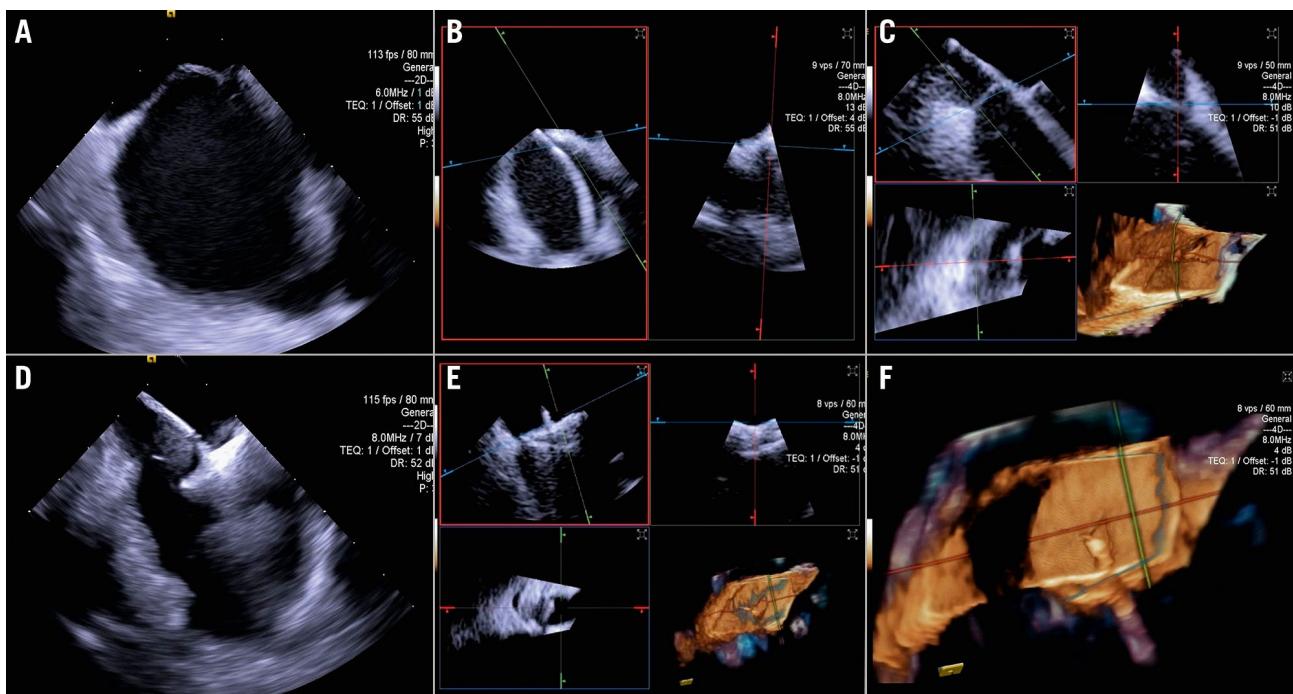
Three-dimensional ICE-guided patent foramen ovale closure. A) 2D imaging allowing assessment of needle tenting in the middle of the fossa ovalis. B) Biplane imaging allowing assessment of the catheter after crossing the septum in the superior-inferior and anterior-posterior positions simultaneously. C) 3D multiplanar reconstruction (MPR) allowing assessment of the catheter after crossing the septum. D) 2D imaging showing the deployment of the right disc of the device. E) 3D MPR allowing simultaneous assessment in the lateral, axial, and azimuthal planes of the right disc of the device. F) 3D reconstruction of the device. 2D: two-dimensional; 3D: three-dimensional; ICE: intracardiac echocardiography
